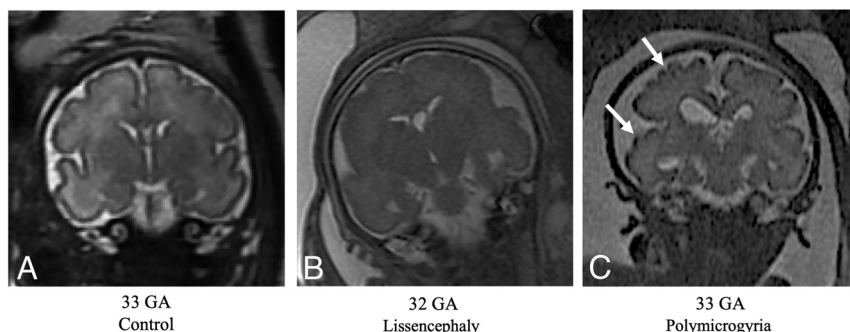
T2-weighted MR imaging of coronal views for controls and fetuses with LIS and PMG of equivalent ages. A, Control fetus, 33 weeks' GA. B, Fetus diagnosed with LIS at 32 weeks' GA, characterized by undeveloped gyration patterns. C, Fetus diagnosed with PMG at 33 weeks' GA, with abnormal excessive gyri (white arrows).
